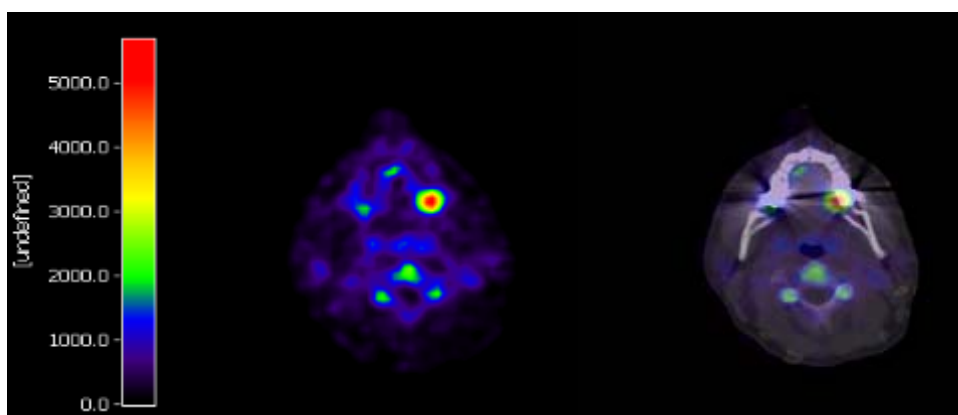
PET-CT image with ^{124}I -F16SIP in head and neck cancer patient showing selective targeting of tumor in lateral tongue
